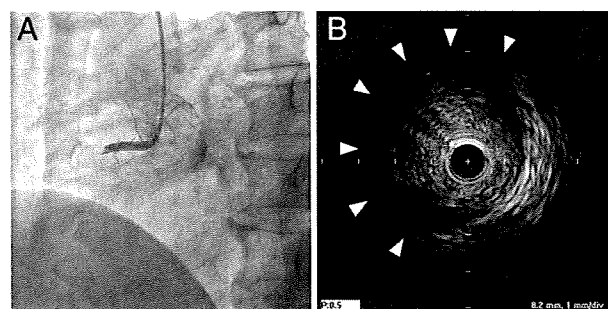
Right coronary angiography revealed an occlusion of the proximal segment of the right coronary artery (A). On intravascular ultrasound examination (B), a near-circumferential attenuation (arrowheads) was observed at the culprit lesion, corresponding with the plaque observed both by multislice computed tomography and by noncontrast T1-weighted magnetic resonance imaging.
